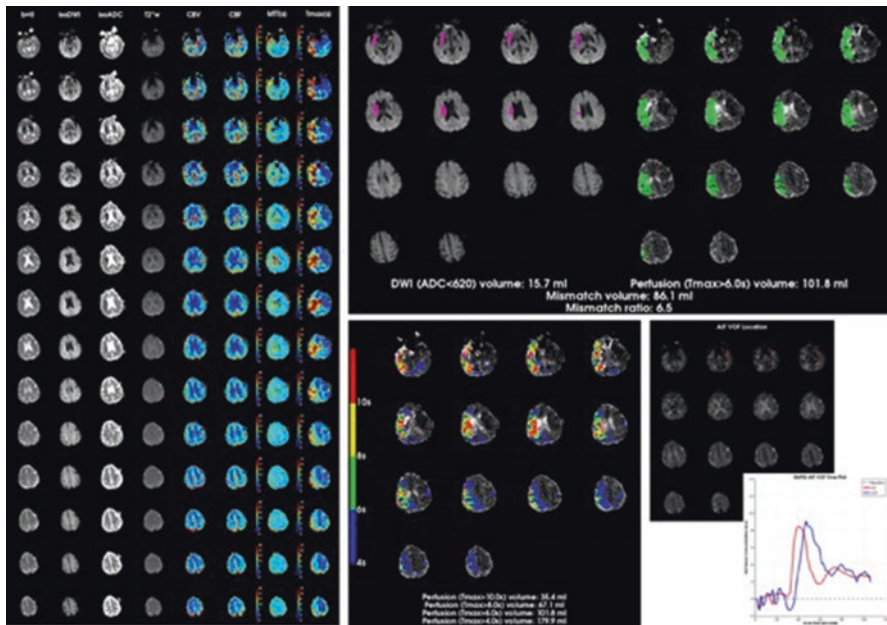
Example of RAPID output images. The RAPID software generates a series of three maps. The column map (*left*) places side-by-side diffusion-weighted images ($b=0$, isoDWI or $b=1000$, and isoADC), T_2^* or gradient echo, and perfusion-weighted images (CBV, CBF, MTT, and T_{\max}). In the CT perfusion output series, the diffusion-weighted and T_2^* images are replaced by the baseline CT, acquired at the onset of the perfusion study. The summary map (*top right*) highlights the ischemic core in *pink*, using an apparent diffusion coefficient (ADC) threshold of $<620 \text{ mm}^2/\text{s}$. The critically hypoperfused lesion is marked in *green*, using a threshold of $T_{\max} >6 \text{ s}$. The severity of hypoperfusion within the ischemic territory is shown in a separate map (*middle*), segmented using T_{\max} thresholds, from >4 to $>10 \text{ s}$. Two reference images (*bottom right*) show the location and time plot of the arterial input and venous output functions
